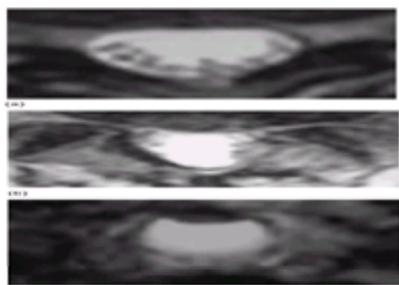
High resolution MRI scans showing the nerve roots (a) normal, (b) arachnoiditis. The nerve roots are adherent to each other, atrophic, and stuck to the wall of the thecal sac. (c) The nerve roots have atrophied completely and can no longer be seen. Residual Myodil is still present anteriorly.
